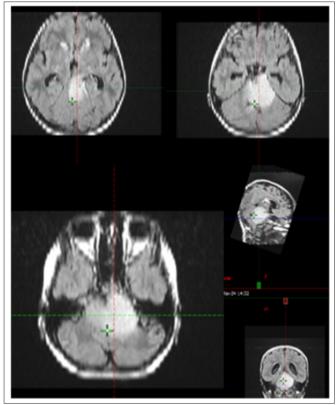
MRI after ventriculoperitoneal shunt placement - MR data of an intraaxial tumor involving the mesencephalon, pons, medulla oblongata and left middle cerebellar peduncles. The formation is located in the middle and more to the left.
